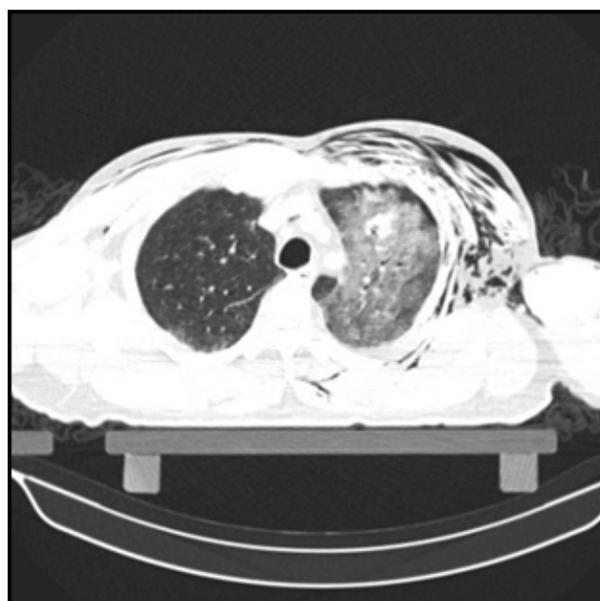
Shows thorax CT imaging
